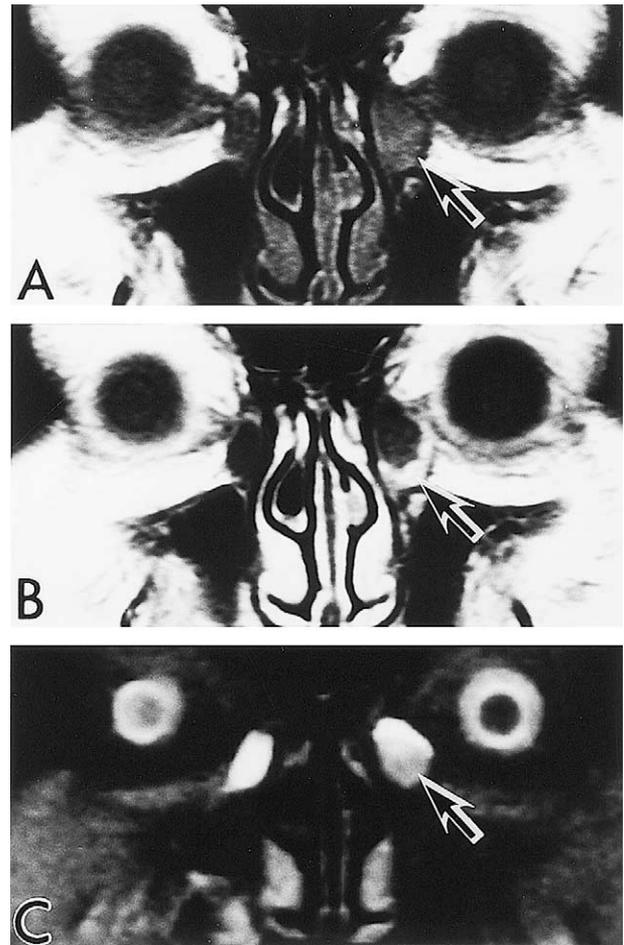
Magnetic resonance imaging coronal sections of a patient (case 13) treated by external dacryocystorhinostomy combined with mucosal grafting. (A) T₁-weighted (TW1) image shows the superior and inferior halves of the left lacrimal sac to be hypointense and slightly hyperintense, respectively (arrow). (B) T1W image after the enhancement with gadolinium-diethylenetriamine pentaacetic acid clearly shows the thick inferior wall of the left lacrimal sac to be hyperintense (arrow). (C) T₂-weighted image shows the superior and inferior halves of the left lacrimal sac to be hyperintense and isointense, respectively (arrow).
